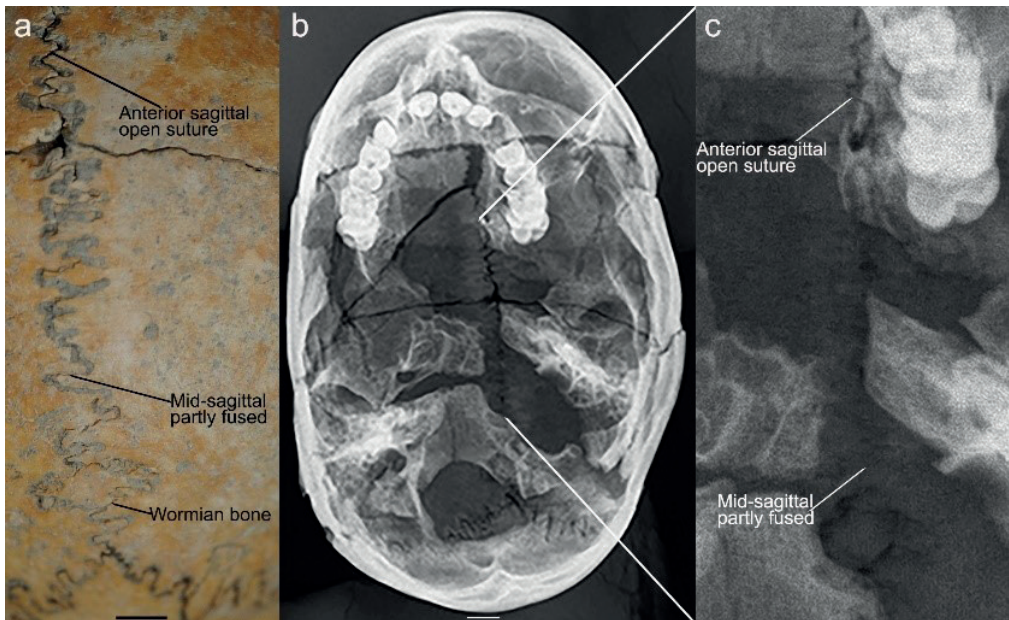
Modřice 3871 cranial vault (a) superior view, showing the mid-sagittal suture ectocranially and a sagittal wormian bone; (b) radiograph of the cranium; and (c) enlarged area on the radiograph showing the mid-sagittal suture; scale bars = 1 cm
